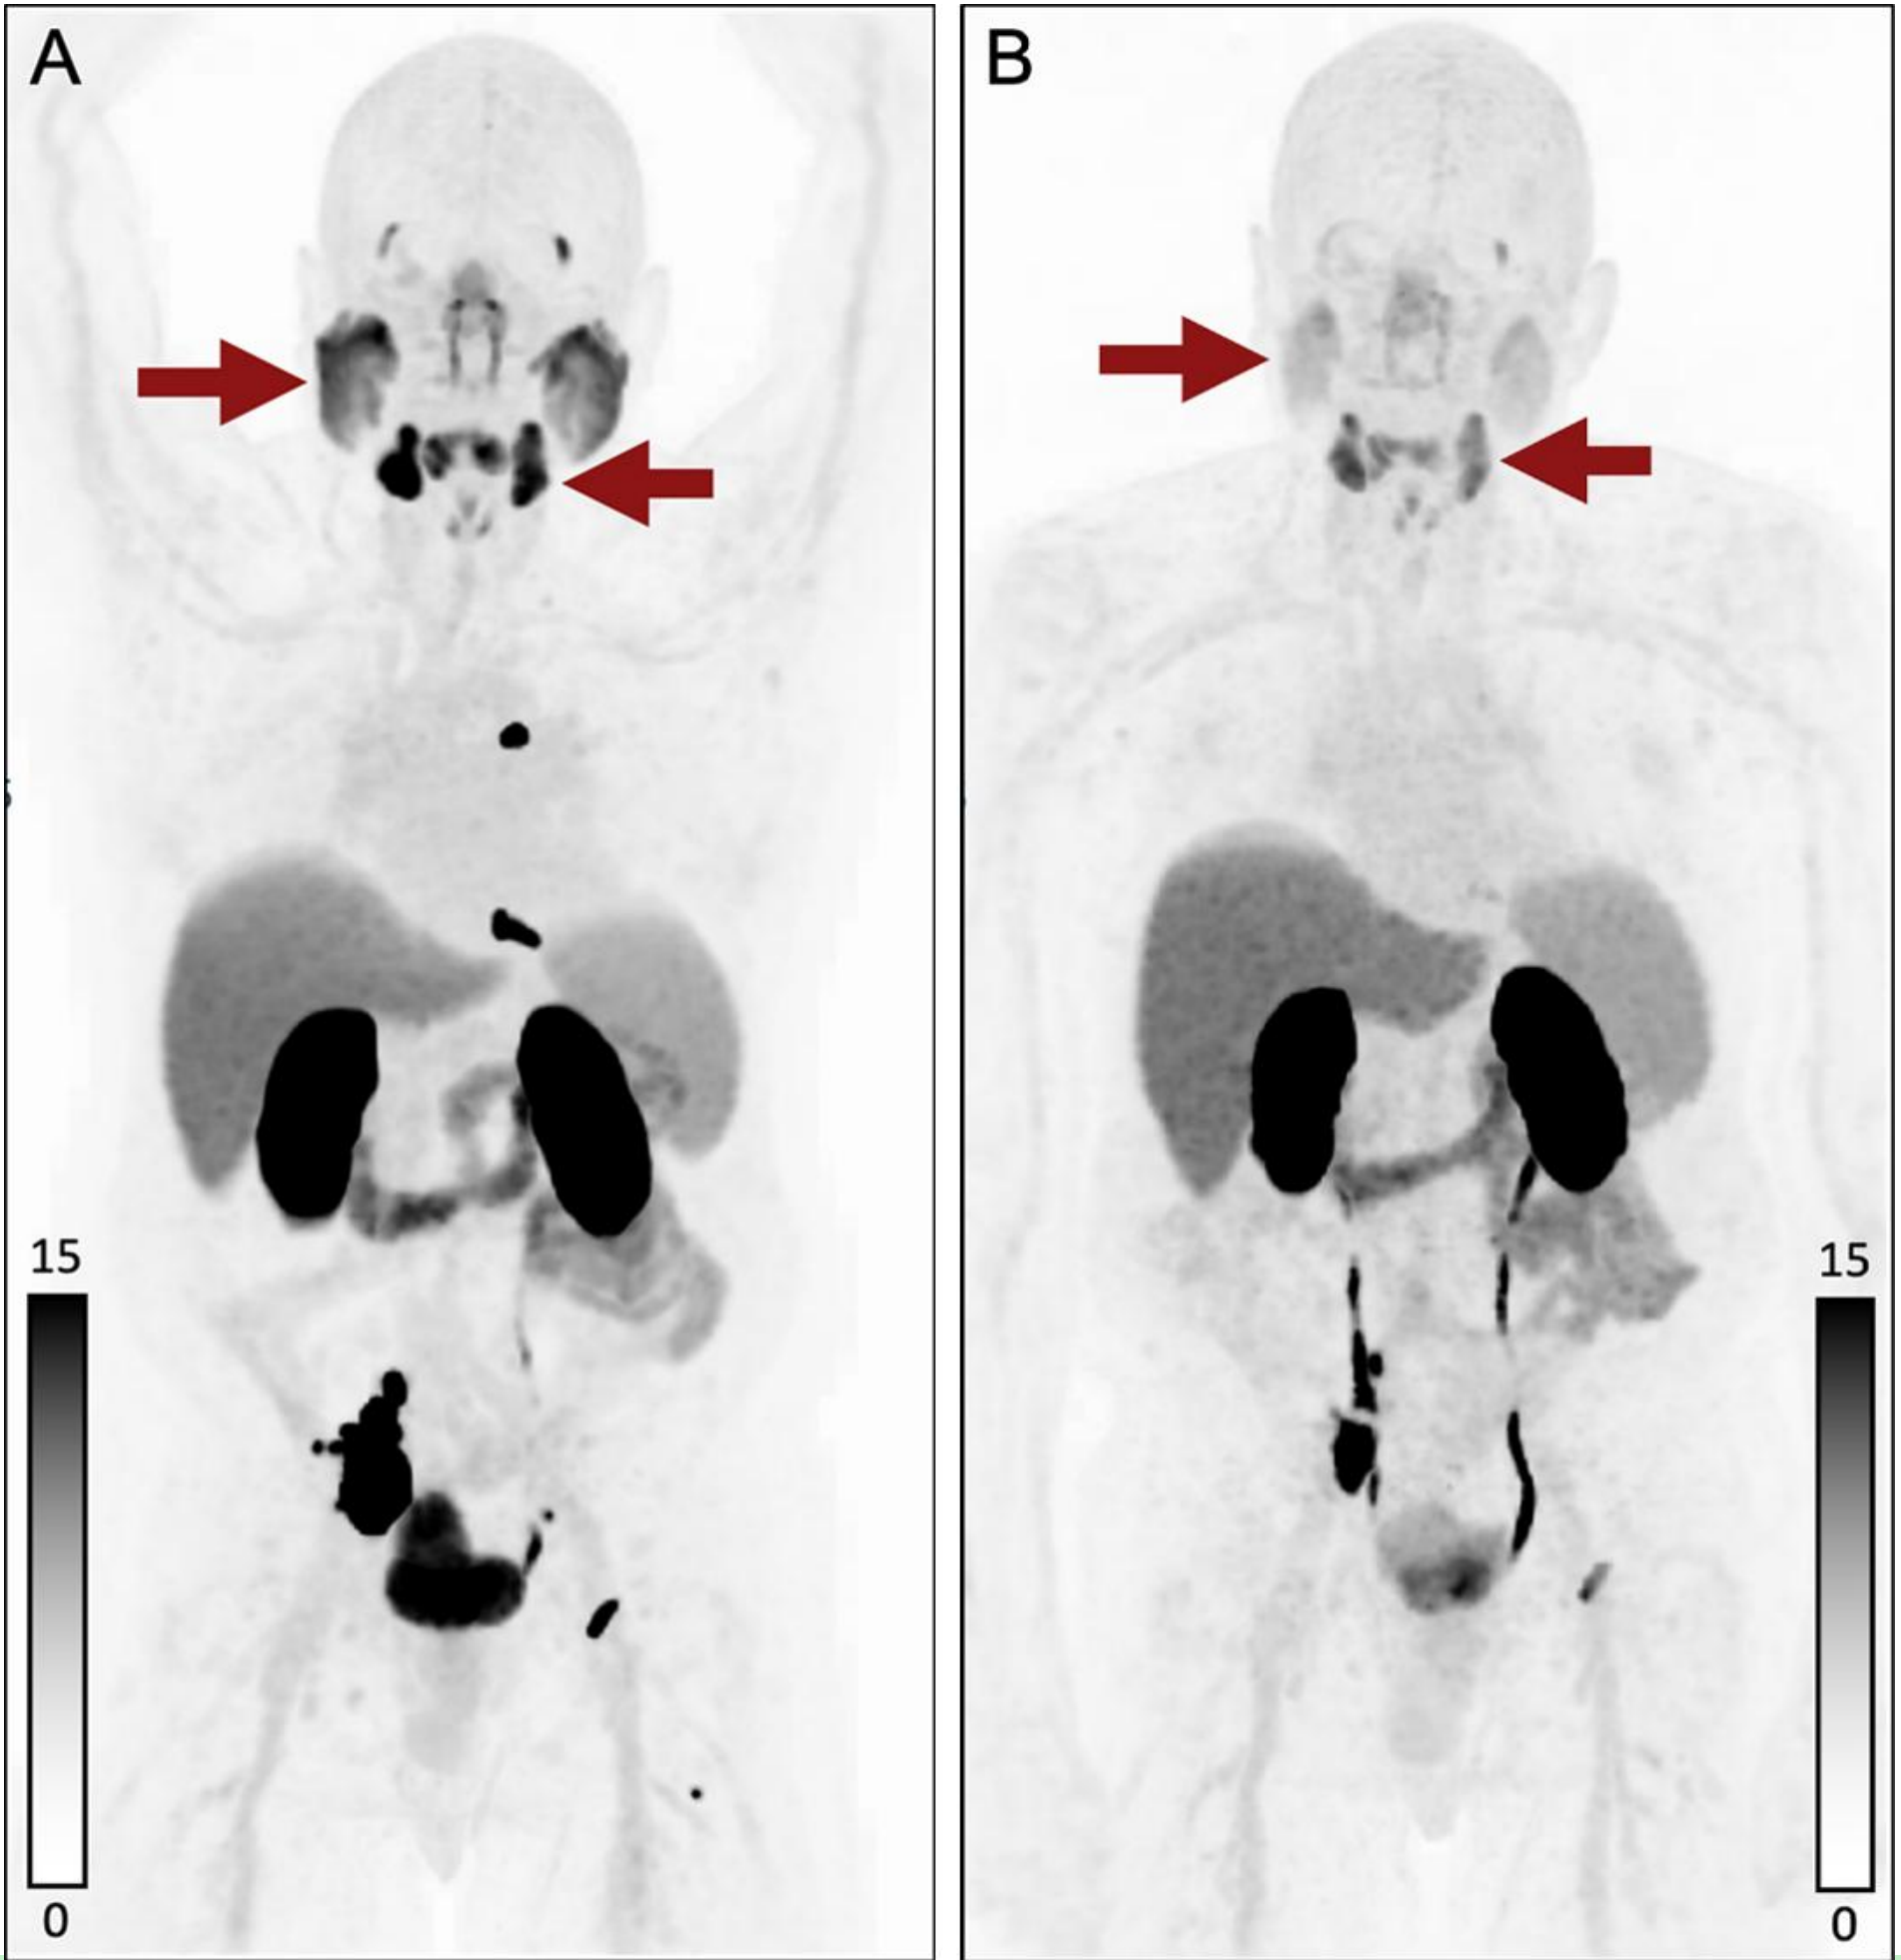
Salivary gland toxicity after ¹⁷⁷Lu–PSMA-617 therapy in an 84-year-old man. The patient had metastatic castration-resistant prostate cancer and was treated with six cycles of ¹⁷⁷Lu–PSMA-617 therapy; he developed symptomatic dry mouth (xerostomia)
